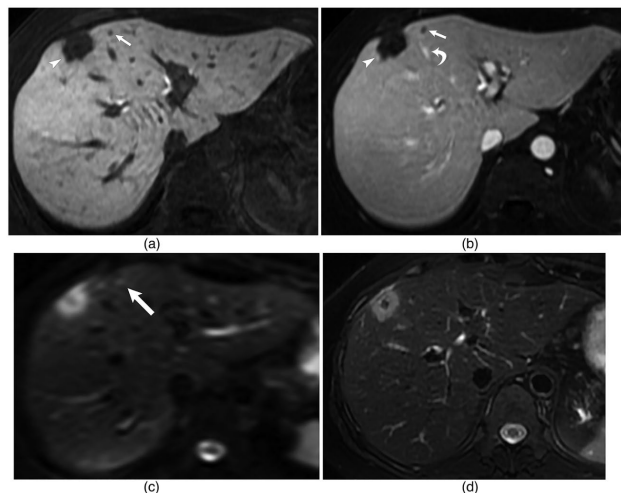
A 60-year-old woman with a history of metastatic colon cancer: (a) 0.5 cm segment 4a lesion on 19 min delayed hepatobiliary phase gadoxetic acid alone sequence and (b) combined ferumoxytol-gadoxetic acid sequence. (c) The lesion is vaguely present on diffusion-weighted imaging, but much less conspicuous. (d) There is no correlate on T2-weighted imaging. Both readers identified the lesion on the combined sequence and failed to identify the lesion on the gadoxetic alone sequence (long arrows). A 2.3-cm metastasis immediately adjacent is easily identified on both sequences (arrowhead). Note the enhancement of a middle hepatic vein branch (curved arrow).
